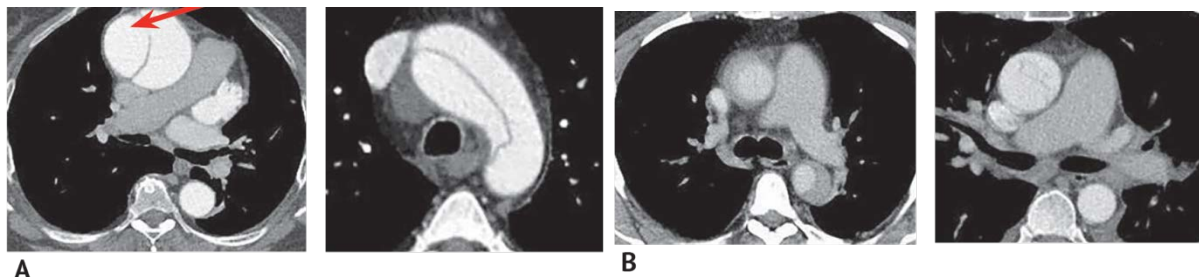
Multislice computed tomography of the aorta with bolus contrast enhancement: A — satisfactory quality of the study, no fenestration in the aortic arch, the arrow indicates the site of primary fenestration in the ascending aorta; B - unsatisfactory quality of research
